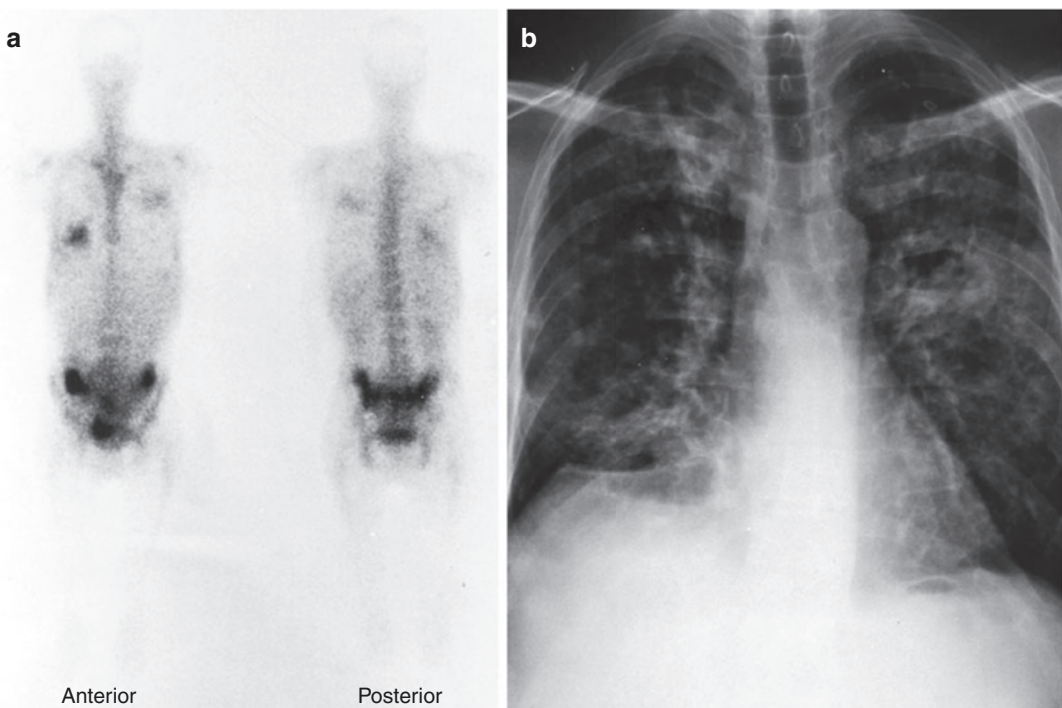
Gallium-67 48-h study (a) shows two areas of increased accumulation of the radiotracer in the right lower and left mid lung zones in a patient with pneumonia. Chest X-ray (b) of the same patient shows infiltrates
